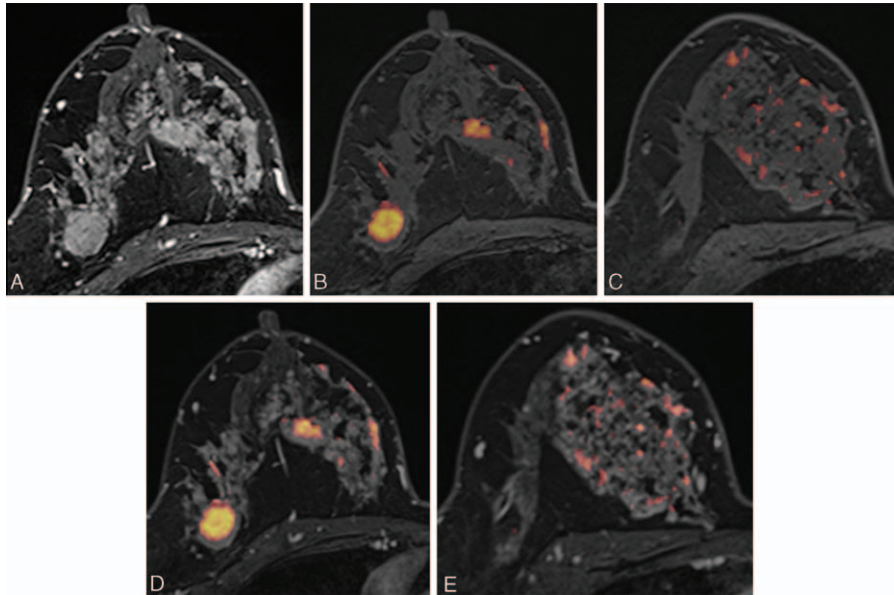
Images of a 46-y-old woman with an invasive ductal carcinoma of the right breast. (A) Axial DCE-MR image shows an irregular enhancing mass in the outer portion of the right breast, which was proven to be an invasive ductal carcinoma. Segmental nonmass clumped enhancement was also present in the upper inner quadrant of the right breast, which was proven to be a 12-cm DCIS. (B, C) UFMR images show a red-colored main mass, which was detected by all 5 readers. A segmental red-colored nonmass lesion was detected by 3 readers. (D, E) For the corresponding lesion, PCFMR images also show a red-colored main mass, which was detected by all 5 readers. The segmental red-colored nonmass lesion was also detected by all 5 readers. DCE-MR = dynamic contrast-enhanced magnetic resonance, DCIS = ductal carcinoma in situ, PCFMR = fused diffusion-weighted imaging using early postcontrast T1-weighted imaging, UFMR = fused diffusion-weighted imaging using unenhanced T1-weighted imaging.
